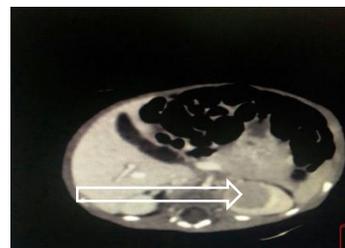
CT Scan Showing Hypodense Space Occupying Lesion
